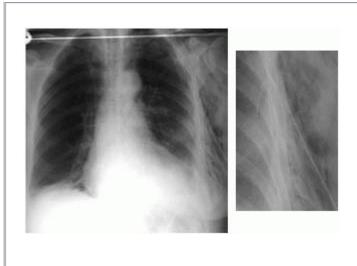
Radiograph showing extensive surgical emphysema on the left of the chest. Insert shows a close-up—you can also see the chest drain that is the cause of the problem.
